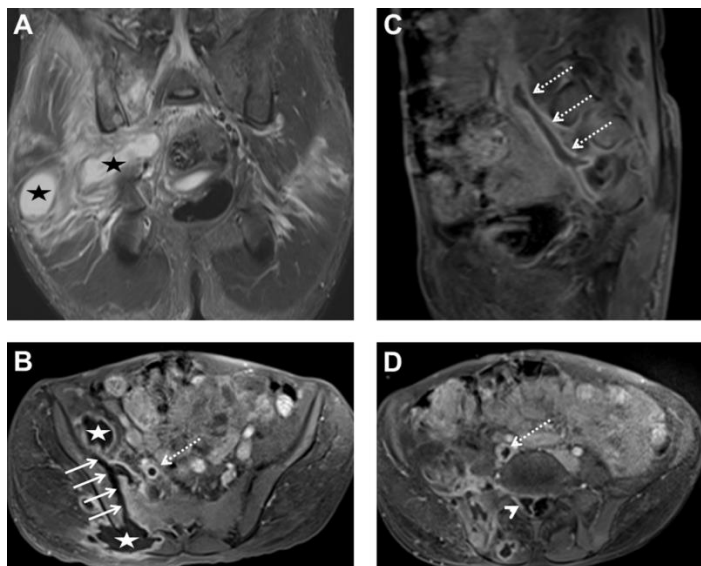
Coronal fat-sat T2 weighted (A) and post-contrast axial fat-sat T1 weighted (B) MR images of the pelvis reveal septic sacroiliitis (arrows) complicated by muscle abscesses (stars). Post-contrast fat-sat T1 weighted (B-D) images also show epidural involvement (arrowhead) of the abscess and right internal iliac vein thrombosis (dashed arrows).
